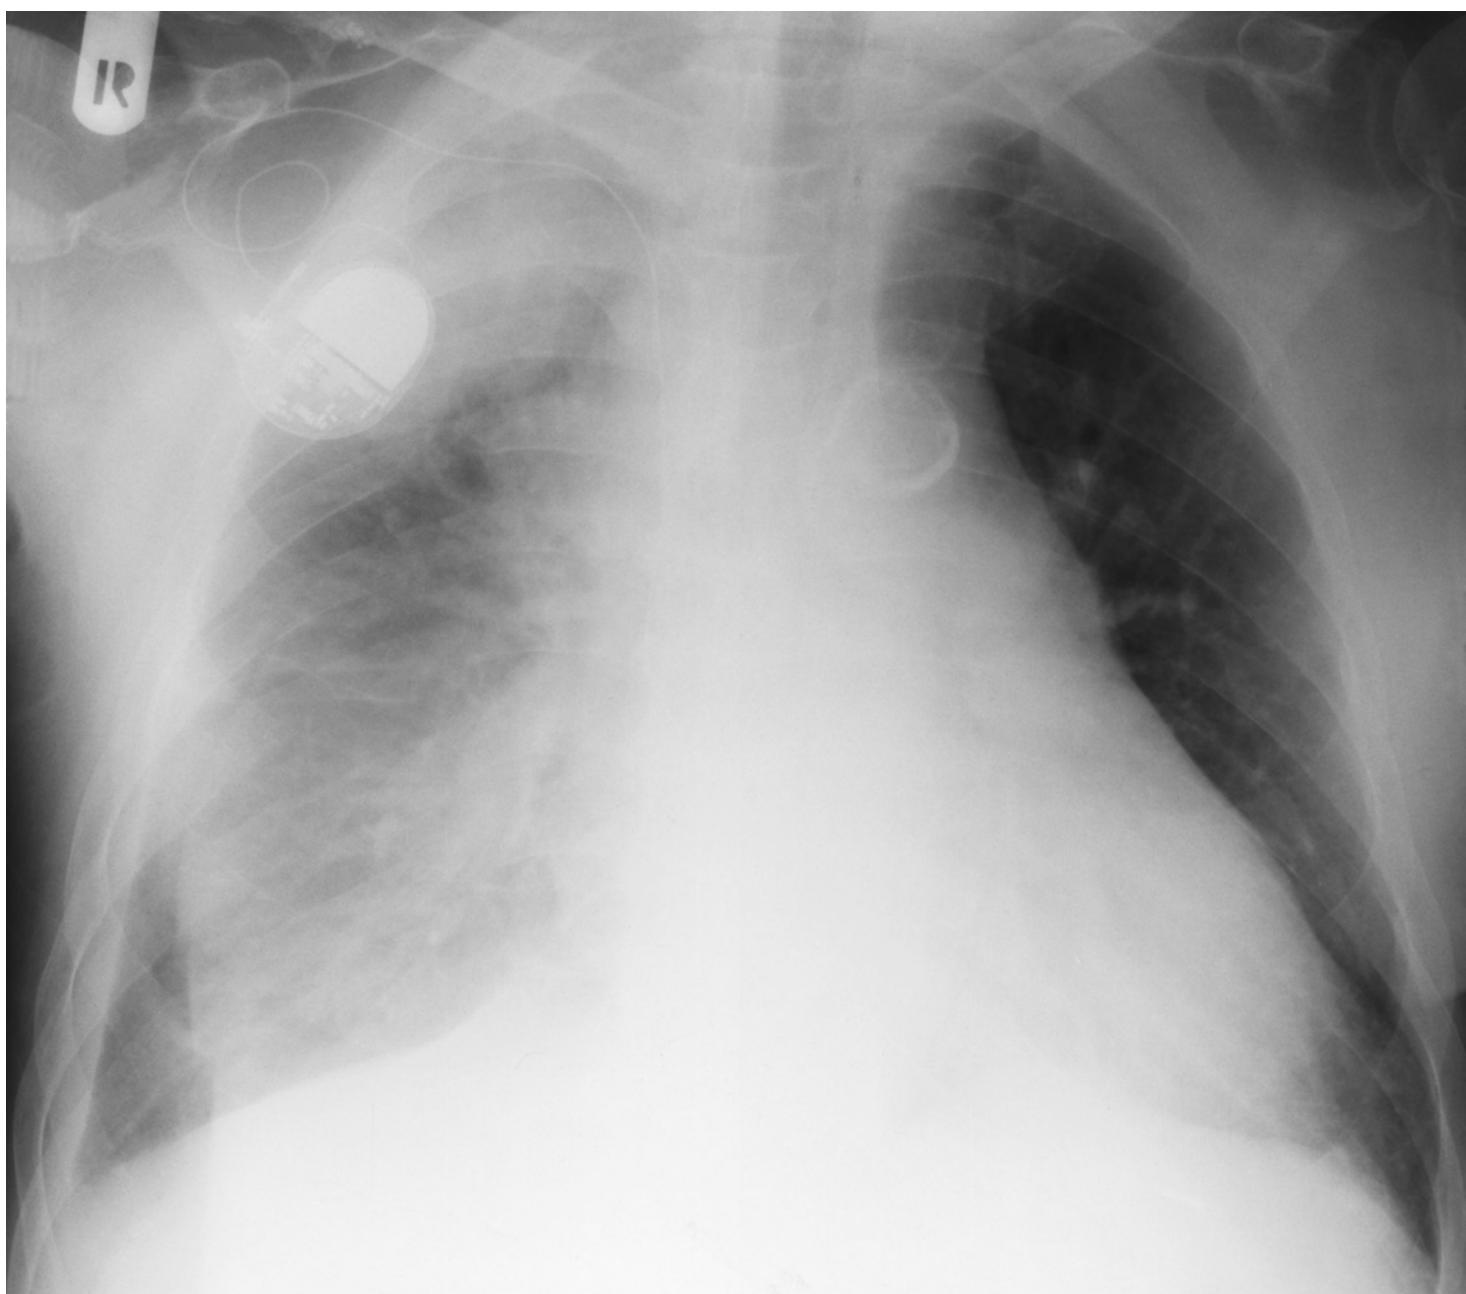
Supine chest radiograph of a 93-year-old man with a long history of coronary heart disease and heart failure, now presenting with dyspnea.
